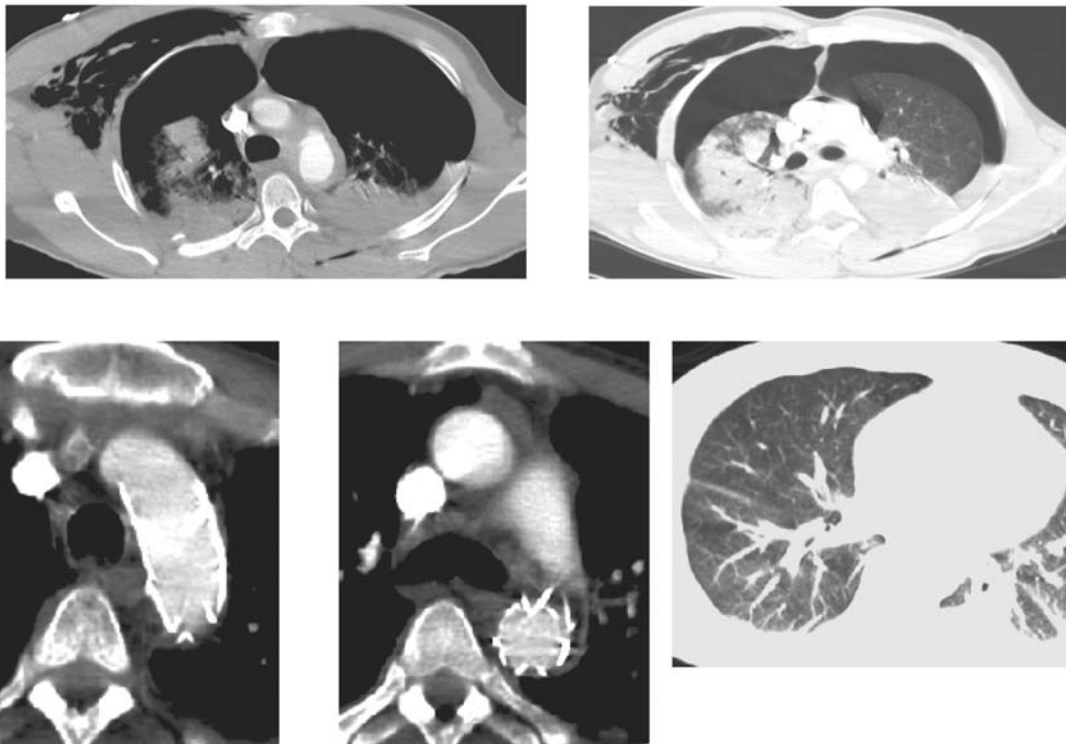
CT scan immediately before and 1 week after implantation. The spiral CT at 1 week shows the complete regression of the pseudoaneurysm with a good apposition of the stent-graft to the aortic wall. The bilateral pneumothorax is also resolved
